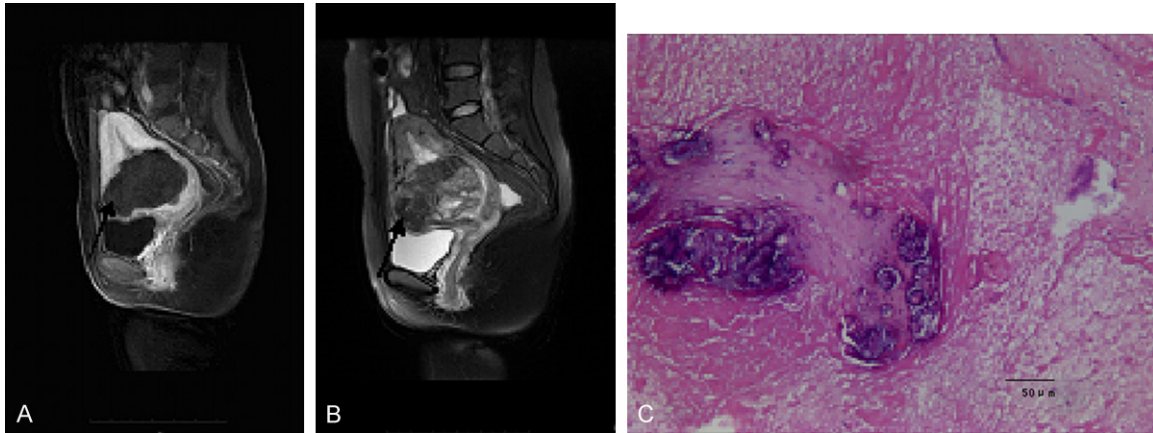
A. A patient with cesarean scar pregnancy at gestation age 14+3 weeks after uterine curettage, sagittal magnetic resonance images showed placenta imbedded in the front wall of uterine cavity close to the cervix (long arrow, enhancement scan). B. The same patient, sagittal magnetic resonance images showed placenta implanted in uterine cavity adjacent to the cervix (arrow indicated, T2-weighted Imaging). C. The same patient resected the uterine scar and its pregnant tissue, postoperative pathology showed degenerative necrosis chorionic villi, trophoblastic tissue and blood clot with calcification, 100 \times .
